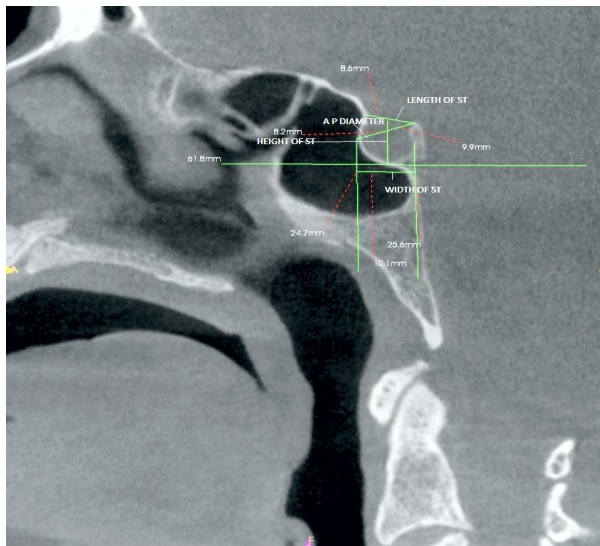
The sagittal section (CBCT) showing the measurements of study parameters in male subjects
